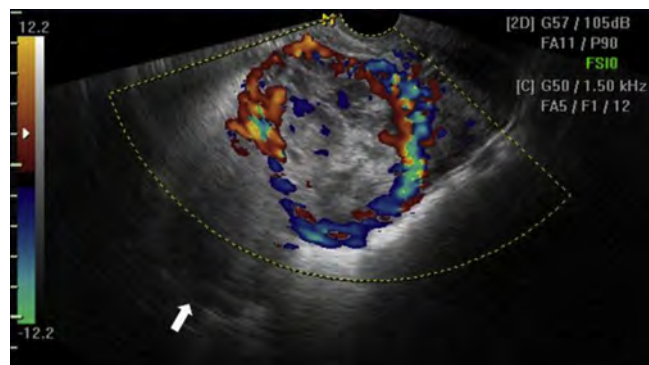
Color Doppler ultrasound showing numerous tortuous blood vessels encompassing the tumor in the anterior isthmus region of the uterus (arrow, uterine fundus).
